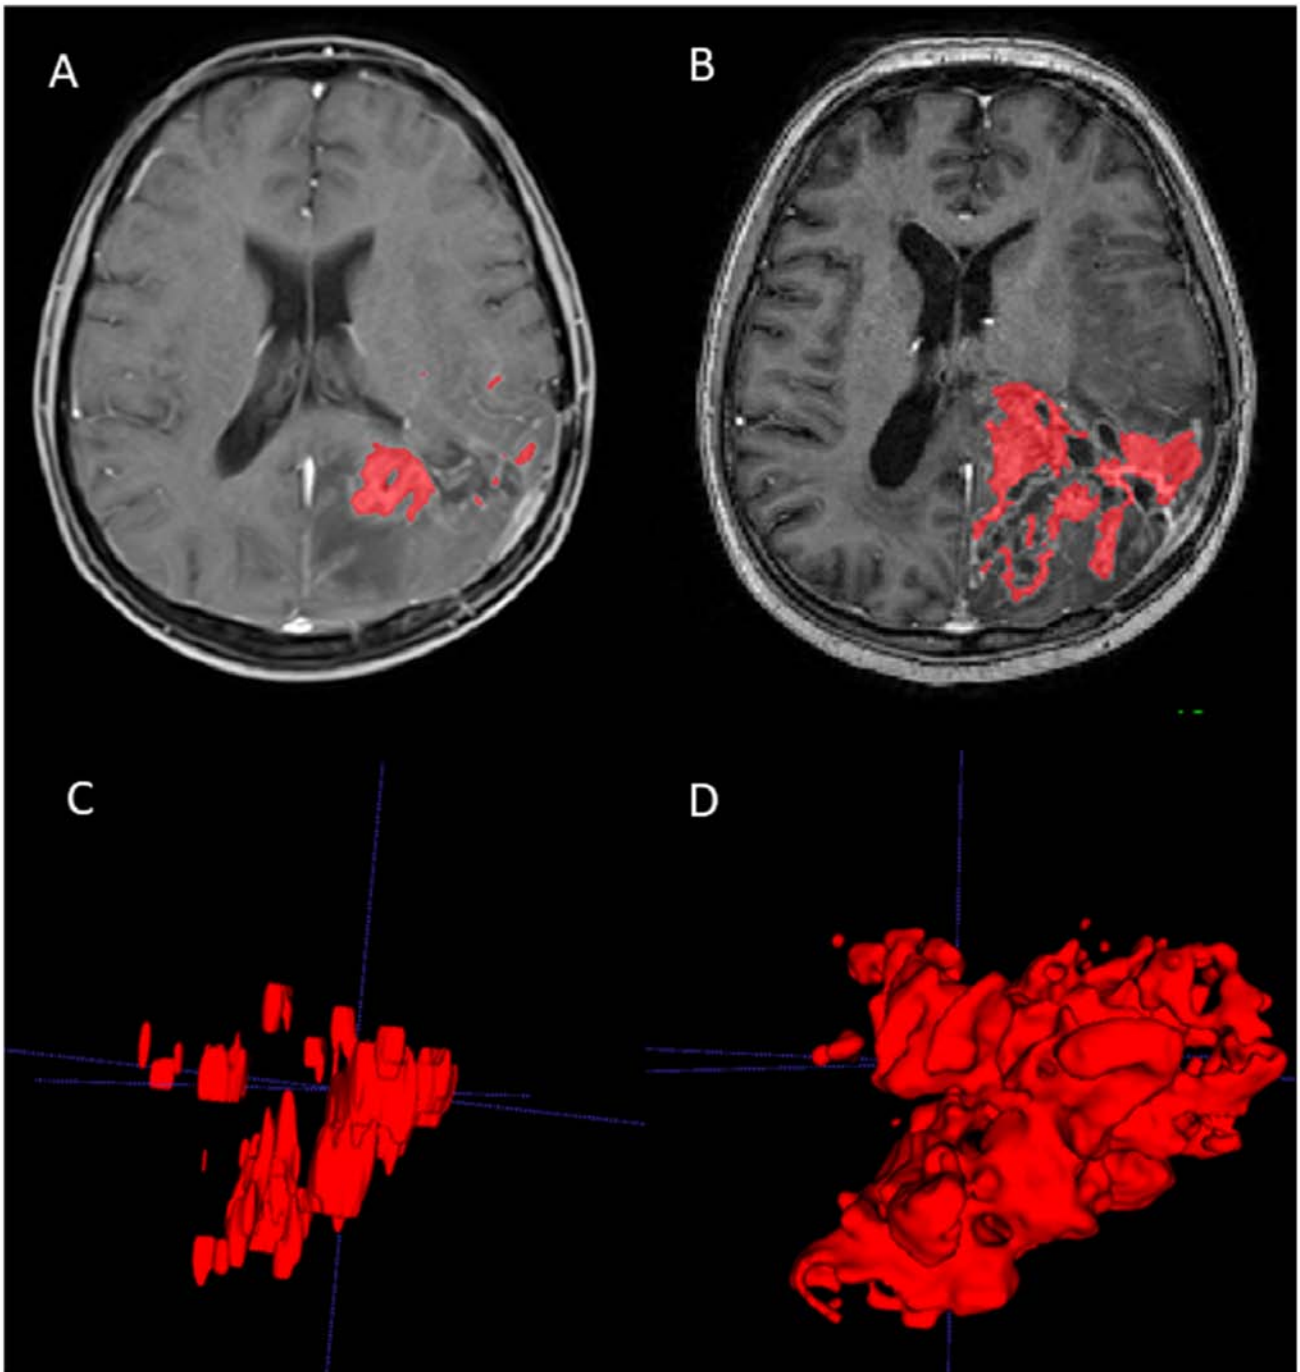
Example of tumor segmentation (A and B) on 3-dimensional-T1-weighted magnetic resonance imaging (A) before and (B) after FTM treatment and (C and D) 3D reconstruction (C) before and (D) after FTM treatment. FTM, fotemustine.
